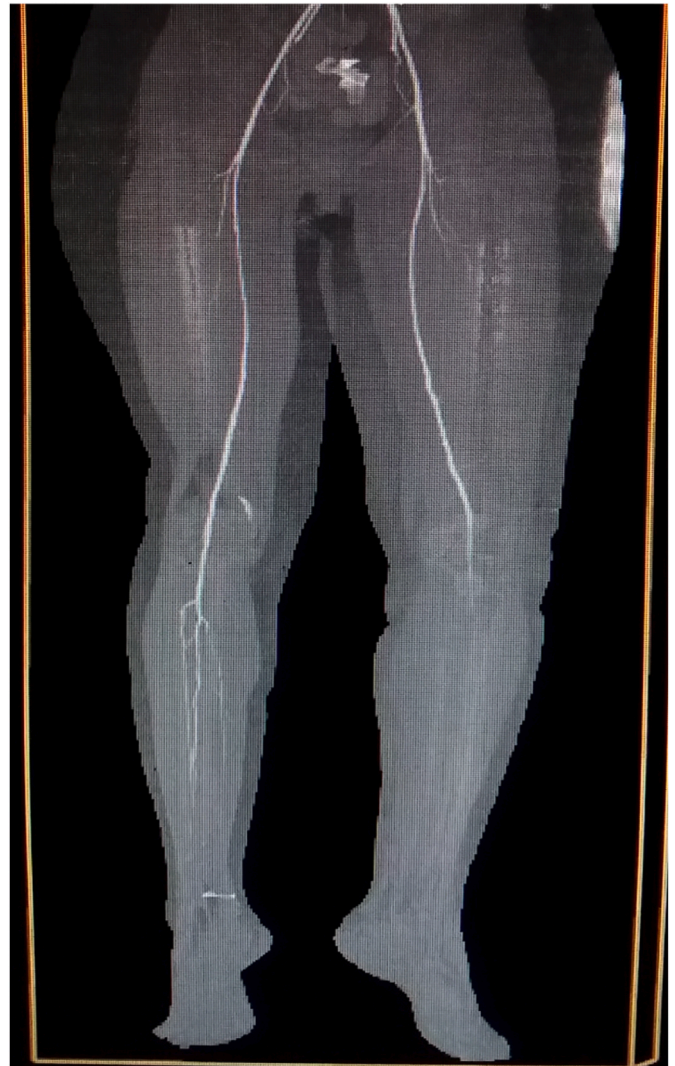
CT Angioscan of the lower limbs.
